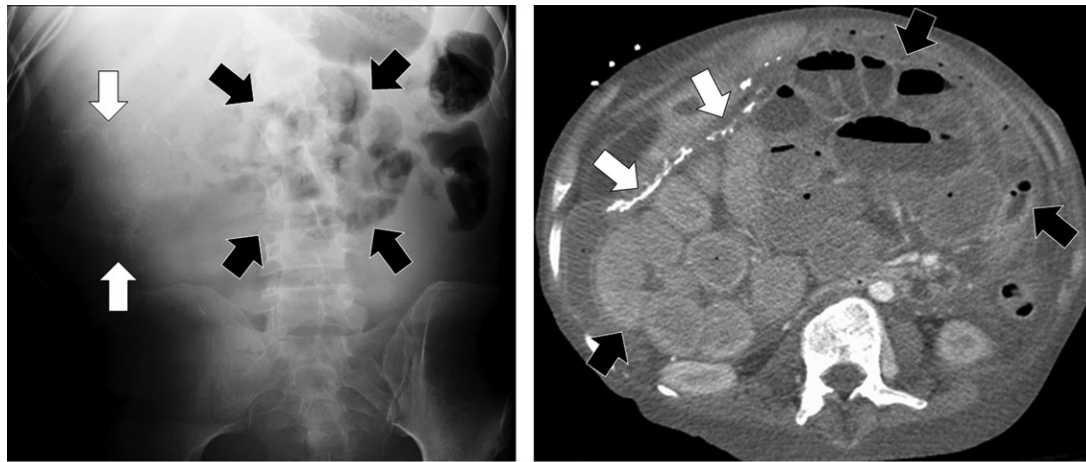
EPS in a 26-year-old man after lung transplantation (same patient as shown in Fig 10). (a) Anteroposterior radiograph shows calcifications in the right flank (white arrows) and a nonspecific pattern of small-bowel loops (black arrows) clustering in the mid portion of the abdomen. (b) Axial contrast-enhanced CT image helps confirm the thickened enhancing peritoneal membrane (black arrows), a finding that is in keeping with EPS. The membrane is calcified (white arrows) on its anterior aspect. (A full DICOM image stack is available online.)
